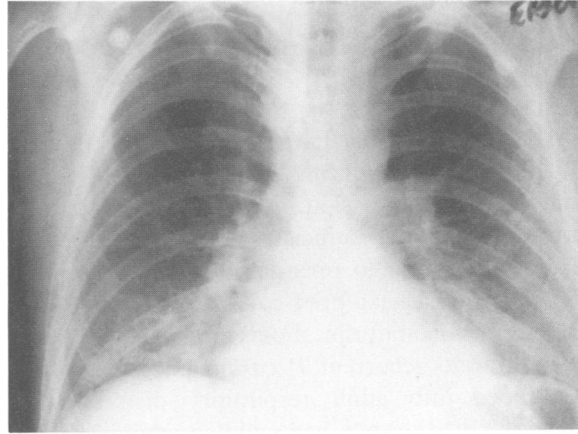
X-ray film of the chest taken on the first day of patient's second University of California admission, showing classic interstitial infiltrates associated with *Pneumocystis carinii* pneumonia.
